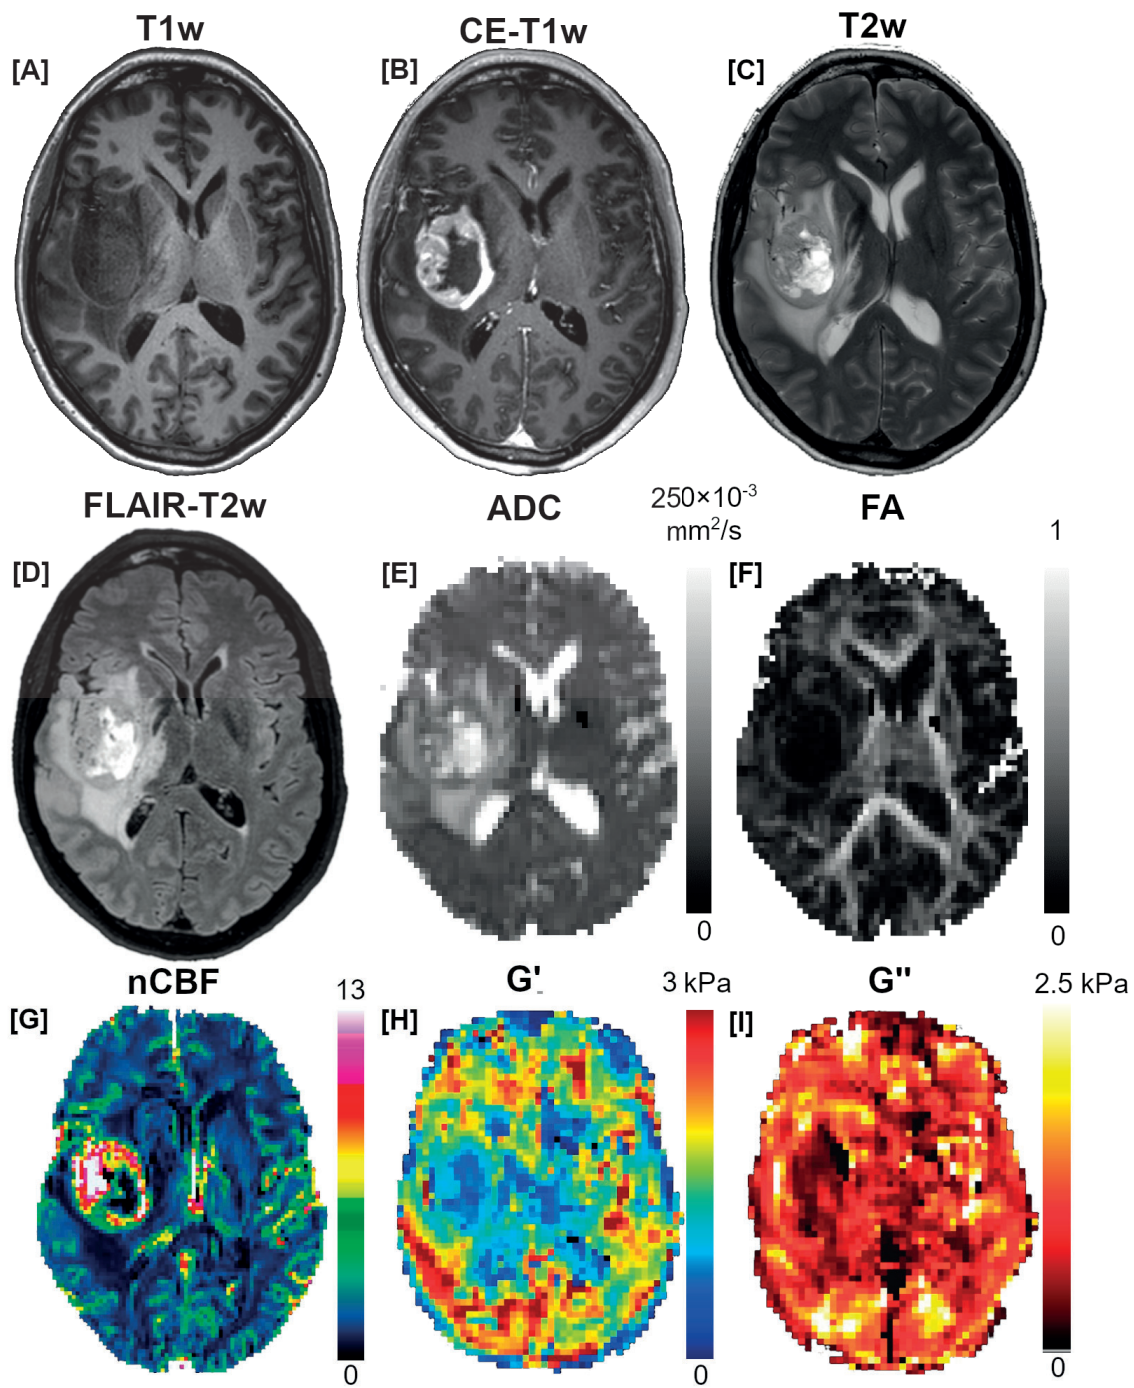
MR images of patient with GBM. The tumor is visible as an oval mass on the left side of the images. A) T1-weighted (T1w), B) contrast-enhanced T1-weighted (CE-T1w), C) T2-weighted (T2w), D) fluid-attenuated inversion recovery (FLAIR-T2w), E) apparent diffusion coefficient (ADC), F) fractional anisotropy (FA), G) normalized cerebral blood flow (nCBF), H) shear storage modulus G' , I) shear loss modulus G''
